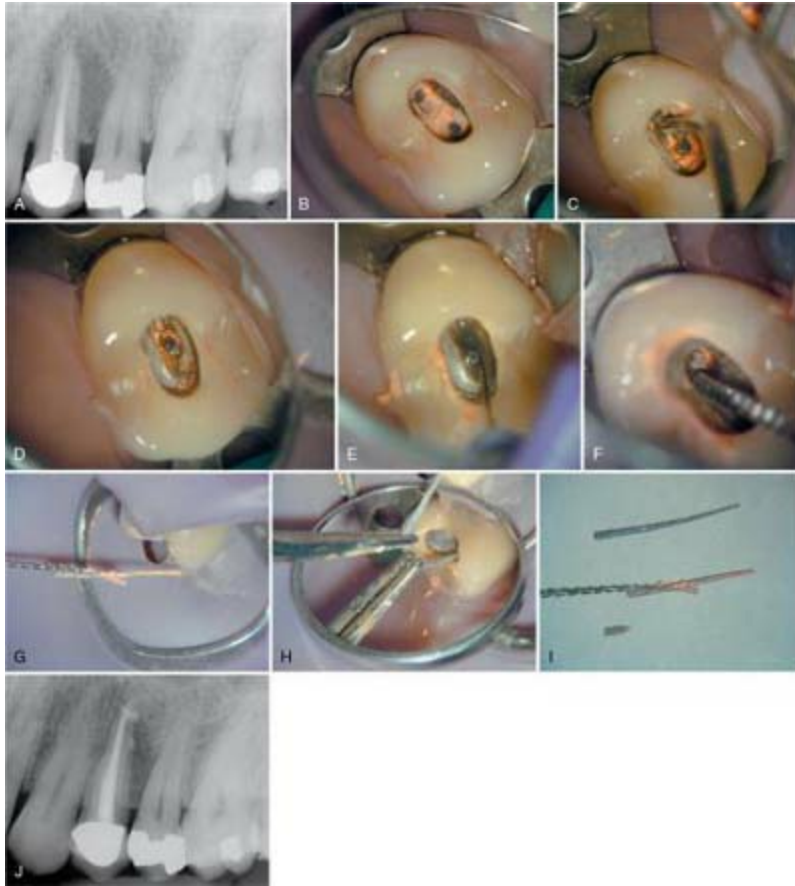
Plastic carrier retreatment. A, Preoperative radiograph. At this stage, the nature of the root filling is unknown. B, Plastic carriers visible in the access as two black spots in the gutta percha mass. C, Gutta percha in the chamber is carefully removed from the carriers. D, Carrier is exposed. E, Chloroform solvent is placed into the chamber and a small file is worked alongside the carriers to remove the gutta percha. F and G, A Hedstrom file is gently screwed into the canal alongside the carrier and withdraws it on removal. H, A hemostat removes the other carrier. I, Plastic carriers removed. J, Final obturation with Resilon and Epiphany sealer.
